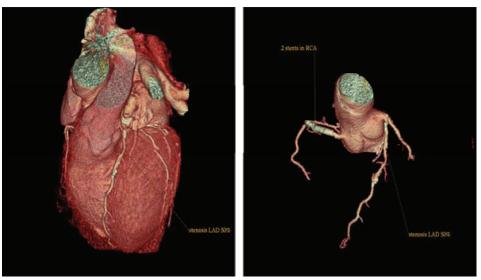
Cardiac computed tomography. 3-D reconstruction of coronary angiography in the same patient.
